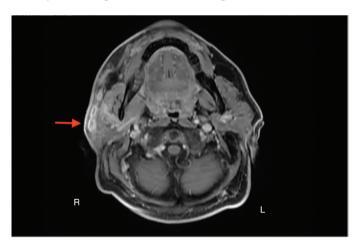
Peripheral enhancing abscess formation in the posterior region of the right mandible shown on a fat-suppressed contrast-enhanced T1-weighted axial MRI image
